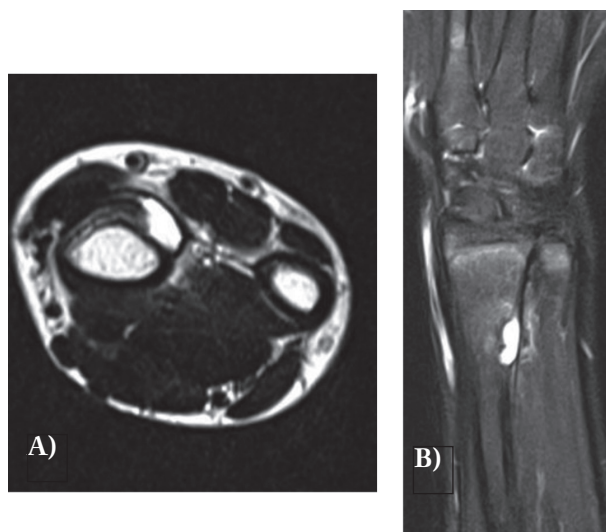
A, B. MRI of the cystic lesion
